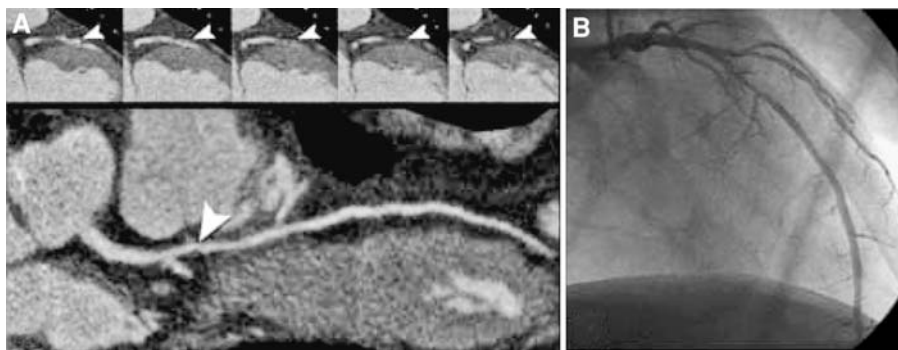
Example of lesion missed at CT because of motion artifact. The patient underwent the scan with a heart rate of 75 bpm. The CT images (A) performed in longitudinal curved multiplanar reconstruction (A – lower image) and in longitudinal multiplanar (A – upper images) show a vessel wall thickening of the proximal left anterior descending artery (arrowheads). The conventional coronary angiography instead demonstrates a significant lesion of the proximal segment of the same vessel (B).
